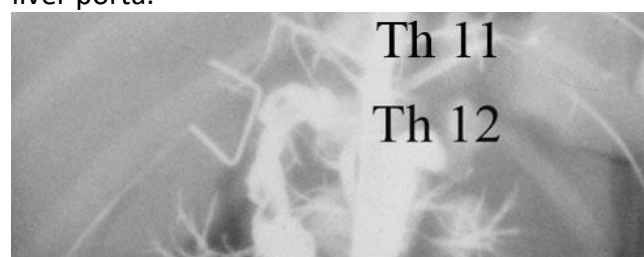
Arteries and duodenum of the fetus (vessels and intestines are filled with injection mixture on the base of red lead). X-ray picture
